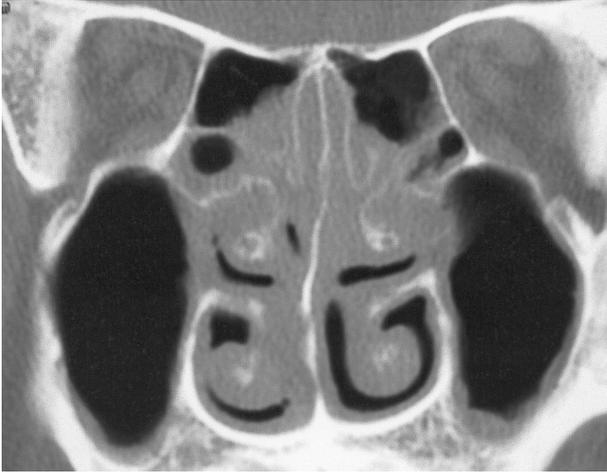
coronal computed tomography of the head showing pus accumulated under the overlying mucoperichondrium.
